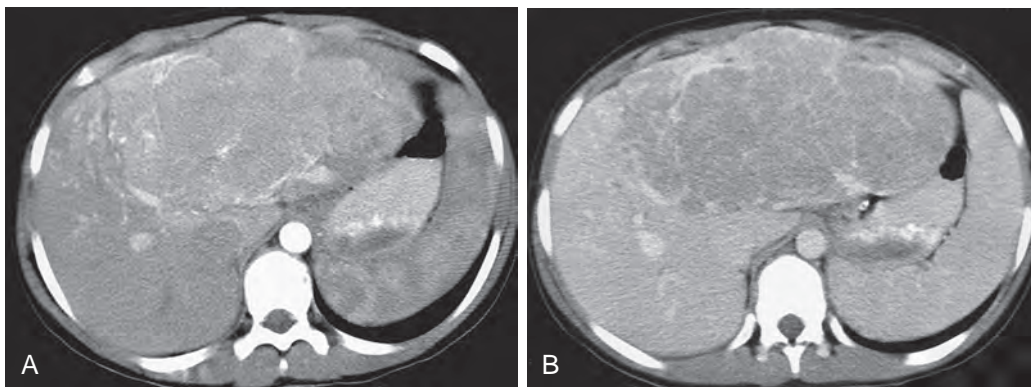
Hepatocellular carcinoma. Arterial phase (A) and portal venous phase (B) dynamic CT through the upper abdomen in a 12-year-old girl who presented with an abdominal mass demonstrates a large, heterogeneous mass with early enhancement on the arterial phase CT scan. The child had no underlying liver disease.
